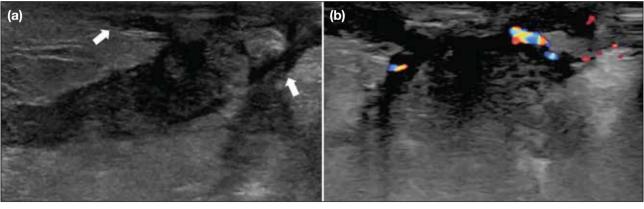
A 27-year-old female presented with a 1-week history of increasing left breast swelling and erythema, which persisted despite antibiotics. (a) Ultrasound showed an irregular hypoechoic mass with tubular extensions (arrows) in the subareolar region of the left breast. There was associated oedema in the adjacent fibroglandular tissue and mild overlying skin thickening. (b) The mass showed peripheral vascularity on colour Doppler, mimicking a breast abscess. Incision and drainage confirmed the diagnosis of granulomatous mastitis. Acid-fast bacilli smear and culture were negative.
